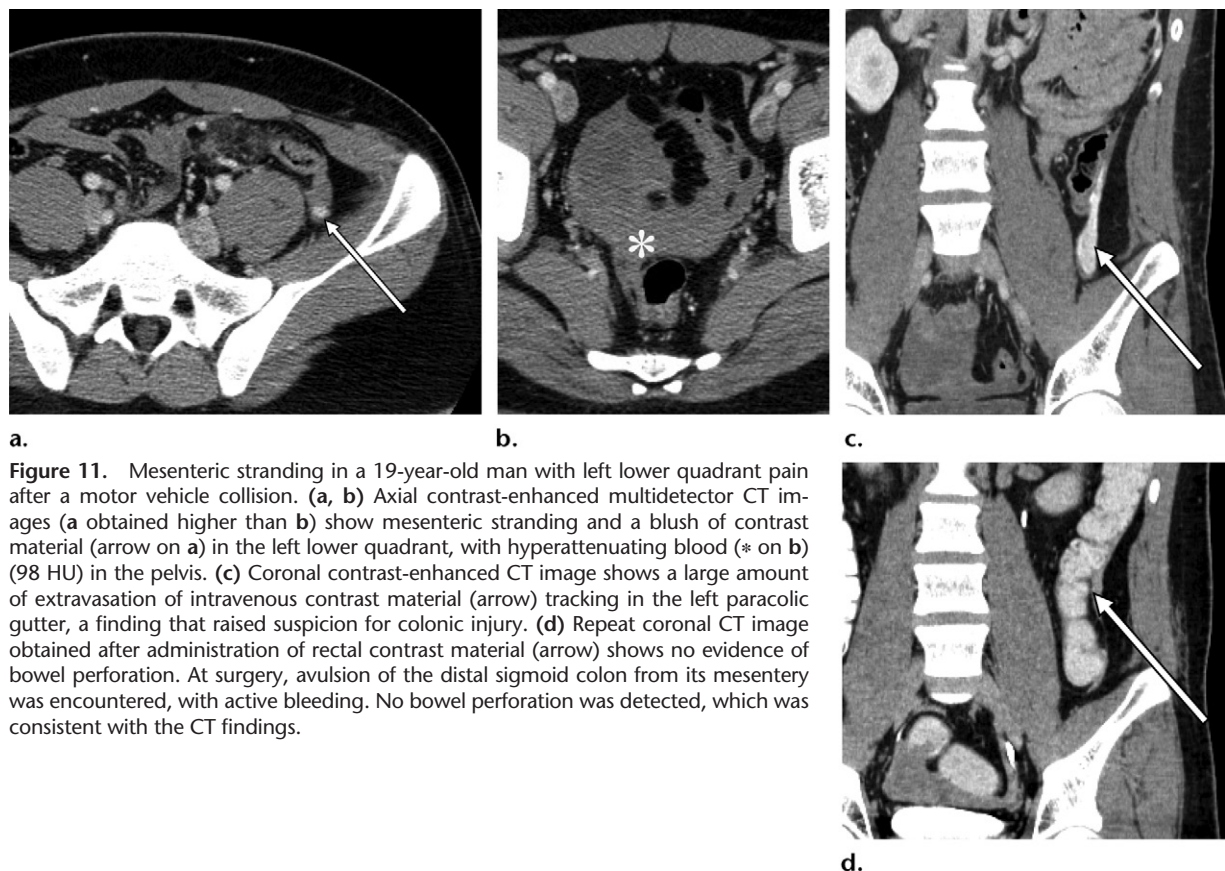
Mesenteric stranding in a 19-year-old man with left lower quadrant pain after a motor vehicle collision. (a, b) Axial contrast-enhanced multidetector CT images (a obtained higher than b) show mesenteric stranding and a blush of contrast material (arrow on a) in the left lower quadrant, with hyperattenuating blood (* on b) (98 HU) in the pelvis. (c) Coronal contrast-enhanced CT image shows a large amount of extravasation of intravenous contrast material (arrow) tracking in the left paracolic gutter, a finding that raised suspicion for colonic injury. (d) Repeat coronal CT image obtained after administration of rectal contrast material (arrow) shows no evidence of bowel perforation. At surgery, avulsion of the distal sigmoid colon from its mesentery was encountered, with active bleeding. No bowel perforation was detected, which was consistent with the CT findings.
